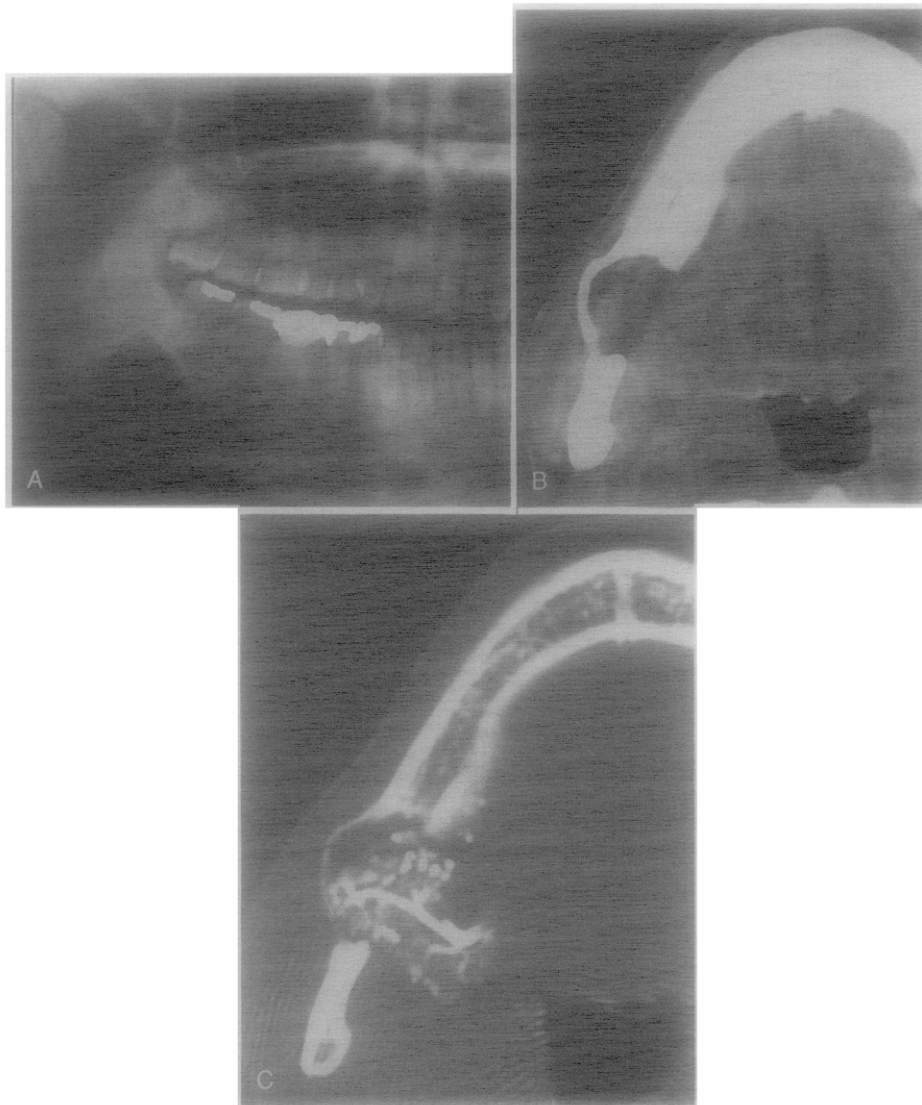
A, Panoramic radiograph of Case 14 shows large radiolucent lesion on right side of mandible. B, Buccal cortical plate extremely expanded laterally. C, Entrapped submandibular gland was confirmed by CT-sialography.
